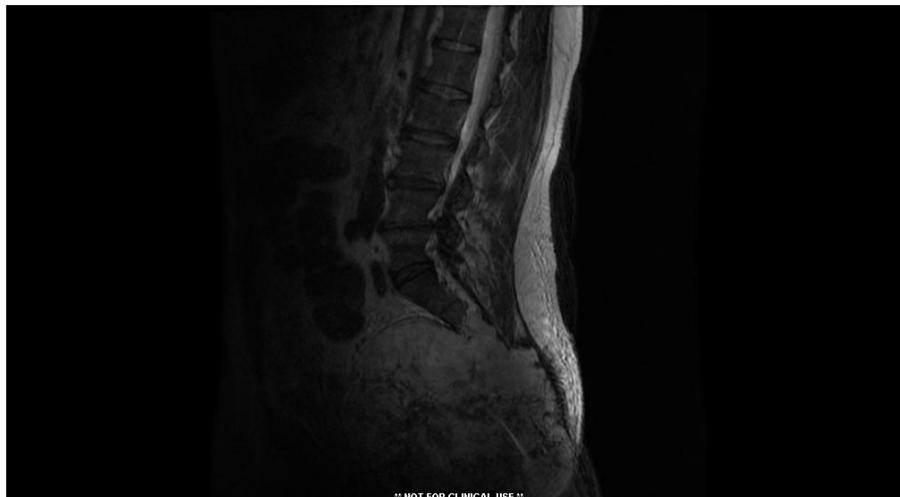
Pre-operative MRI of the sacrum showing a large expansile tumor of the sacrum with significant distortion of the surrounding tissues (The Johns Hopkins Hospital).
